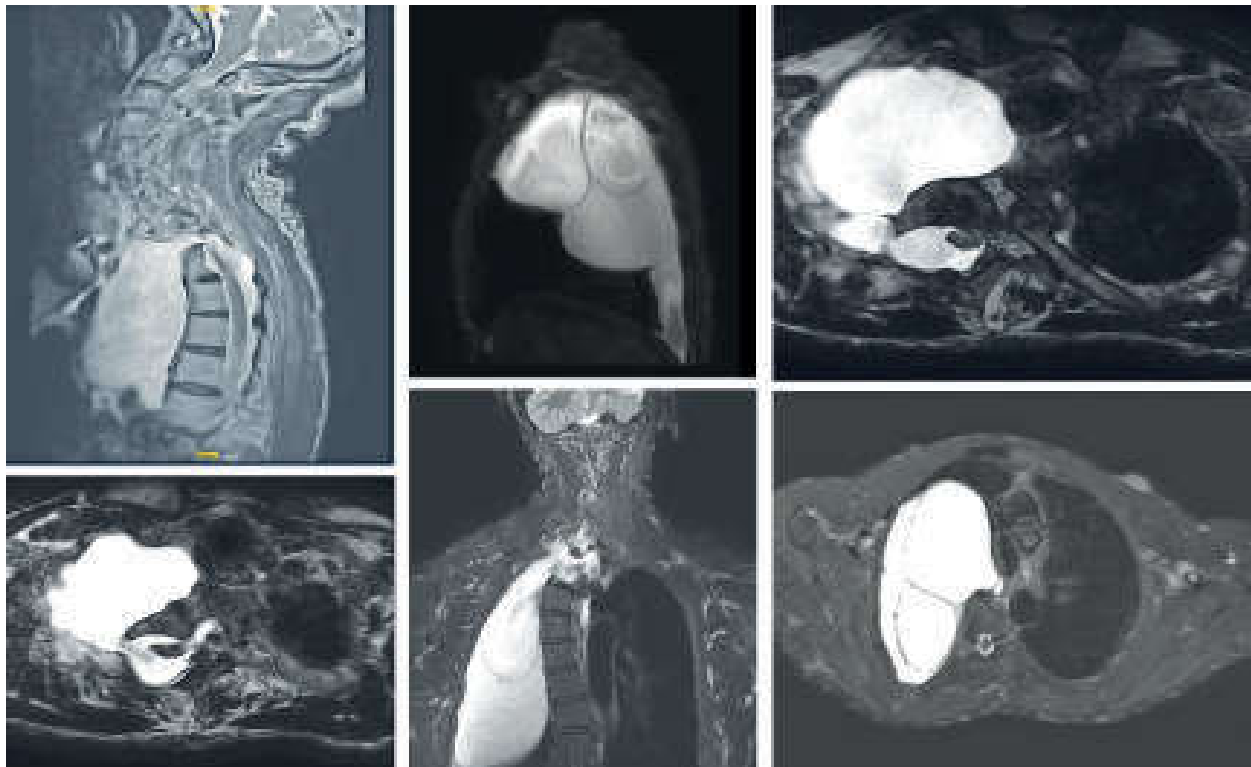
a, b, c, d, e, f: MRI of dorsal spine without contrast showed- large dorsal myelomeningocele due to spinal segmentation fusion anomaly. Multiple enhancing lesions in the visible skin – neurofibromas.
